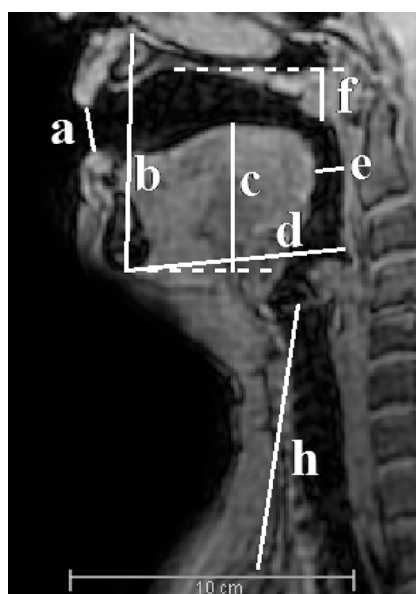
2D MRI measurements: lip opening a , jaw opening b , height of tongue dorsum c , jaw protrusion d , oropharynx width e , uvula elevation f and larynx height h . (oropharynx breadth g , lip spreading i , and vocal tract length j not shown). Figure after [6].
